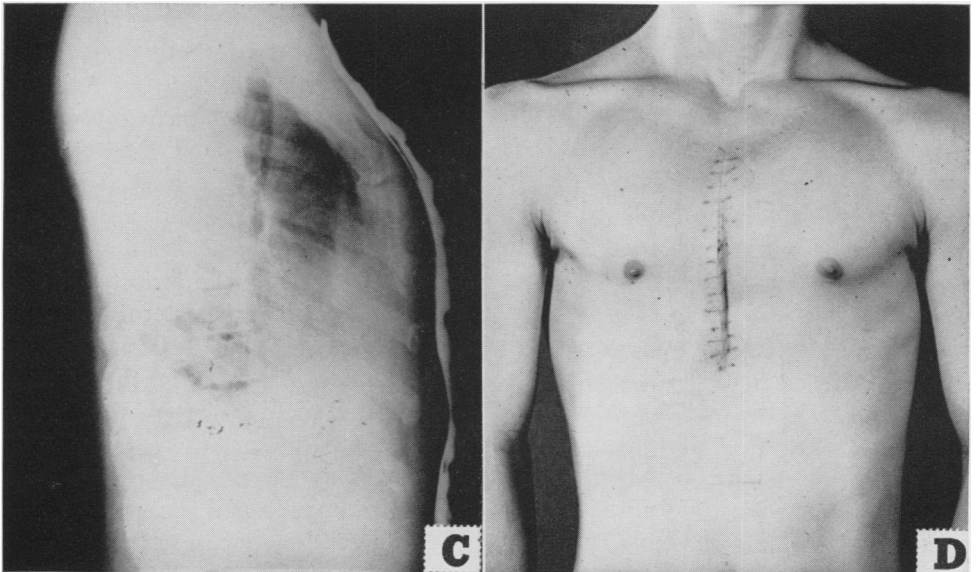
C and D—After operation the chest is normally full and the roentgenogram demonstrates a smoothly continuous curve of the sternum. One of the corrective osteotomies shows plainly. Note that the lateral views of the sternum show no trace of the sternal segments. Currarino and Silverman point out that this type of deformity may be associated with premature fusion of the sternal segments.
